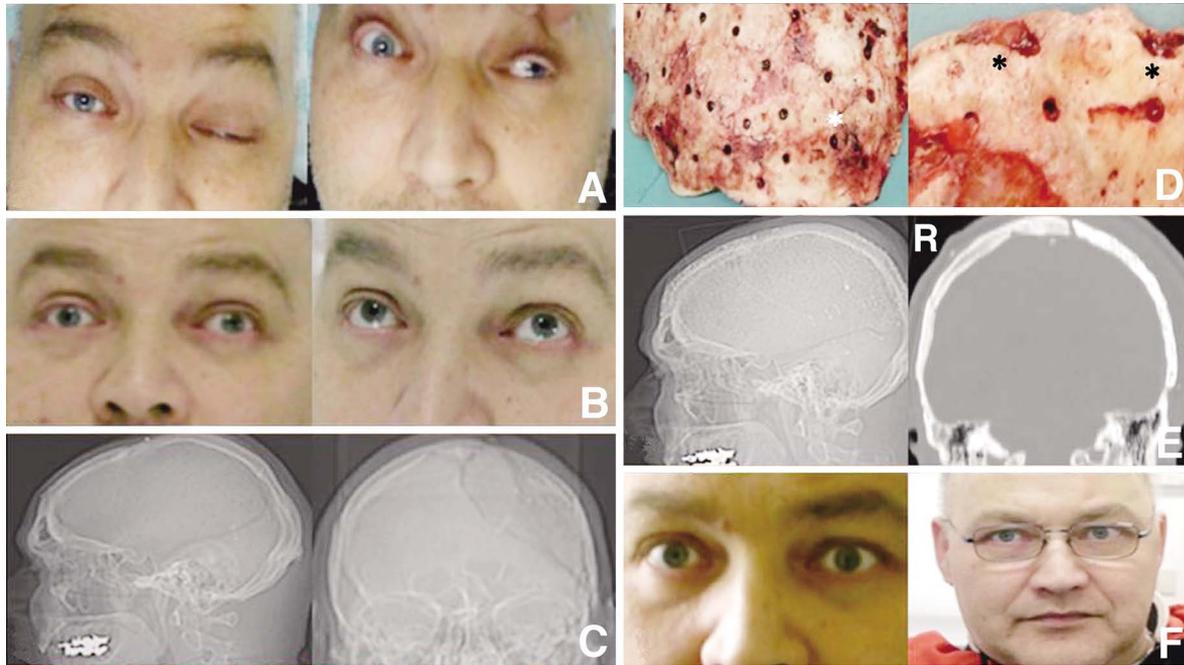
Case 1. A, B: Neurological examination before sinking bone correction showing left ptosis and complete left third cranial nerve palsy appearing after a few minutes in the upright position (A), and ptosis regression and normal ocular movements during the supine position (B). C: Computed tomography (CT) scout views showing incomplete resorption and minimal inward retraction of the re-implanted bone. D: Intraoperative photographs of the removed bone confirming resorption both on the external surface (white asterisk) and on the borders (black asterisks). E: CT scout view and coronal CT scan after porous hydroxyapatite cranioplasty showing regular skull borders. F: Photographs after one month showing the left ptosis and third cranial nerve palsy had fully regressed, also in the upright position.
